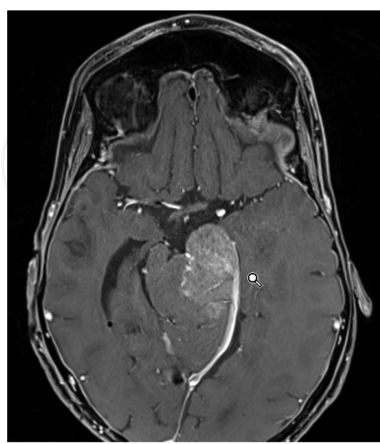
A tentorial meningiomas with less demarcated limits and probably infiltrating the adjacent brainstem. The dural tail is evident in this T1-weighted MRI post gadolinium administration. This 33-year-old patient was irradiated during infancy after the resection of an ependymoma of the IVth ventricle. This may help in explaining the atypical features of the lesion.
